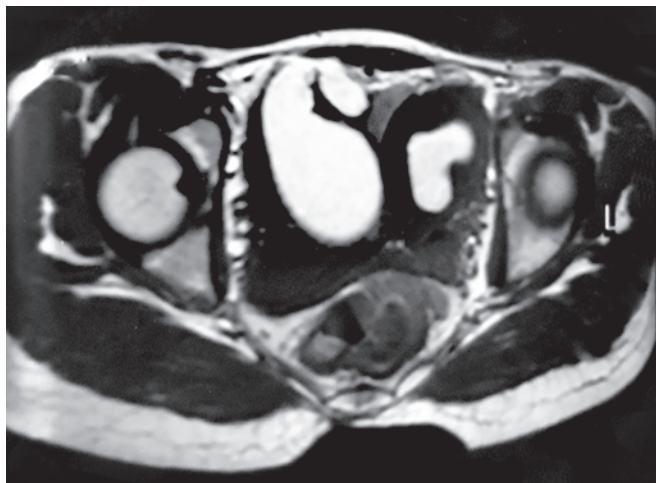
MRI shows unicornuate uterus attached to large left cornu with collection in endometrial cavity of left cornu and hyperintense tubular structure noted seems to be fallopian tube attached to left side of left cornu s/o hematosalpinx
